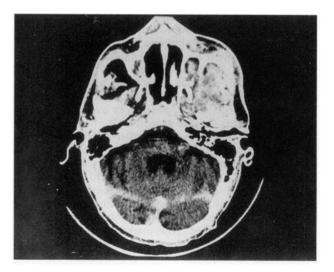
Computed tomography scan shows infiltrating mass of the left maxillary sinus.
